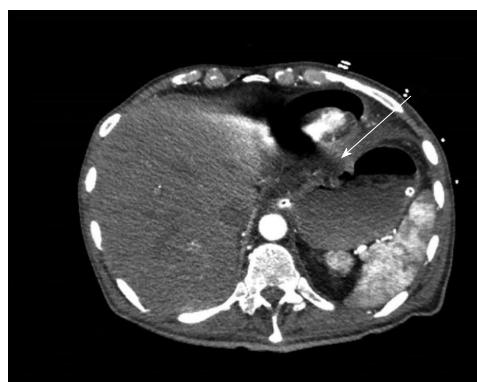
Computed tomography axial section at upper abdominal level revealing the presence of a gastric-pericardial fistula, as denoted by arrow.
